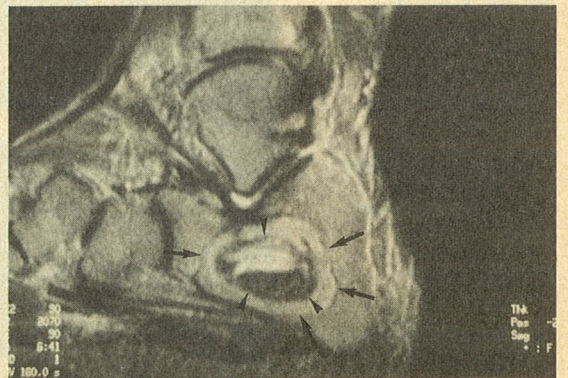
T1-weighted (TR 450 msec, TE 10 msec) spin echo parasagittal MR image of the ankle shows a dark-rimmed (arrowheads) central area containing fluid/fluid levels of low (small asterisk) and intermediate (large asterisk) signal intensities, within the bright lipoma (arrows).
